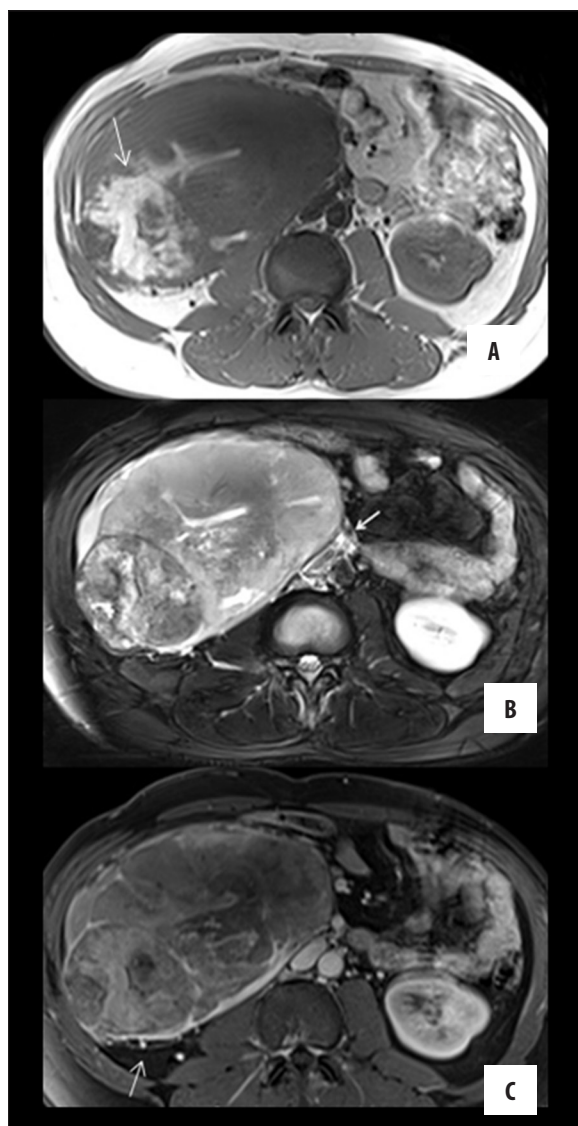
Axial T1-weighted (A), fat suppressed T2-weighted (B) and fat suppressed postcontrast T1-weighted (C) images of the tumor demonstrate its heterogeneous and hemorrhagic (arrow in A) content. Notice the paraaortic metastatic lymph nodes (arrow in B) and heterogeneous enhancement and the increased perirenal vasculature due to rich feeding vessels within the perirenal fat tissue (arrow in C).
